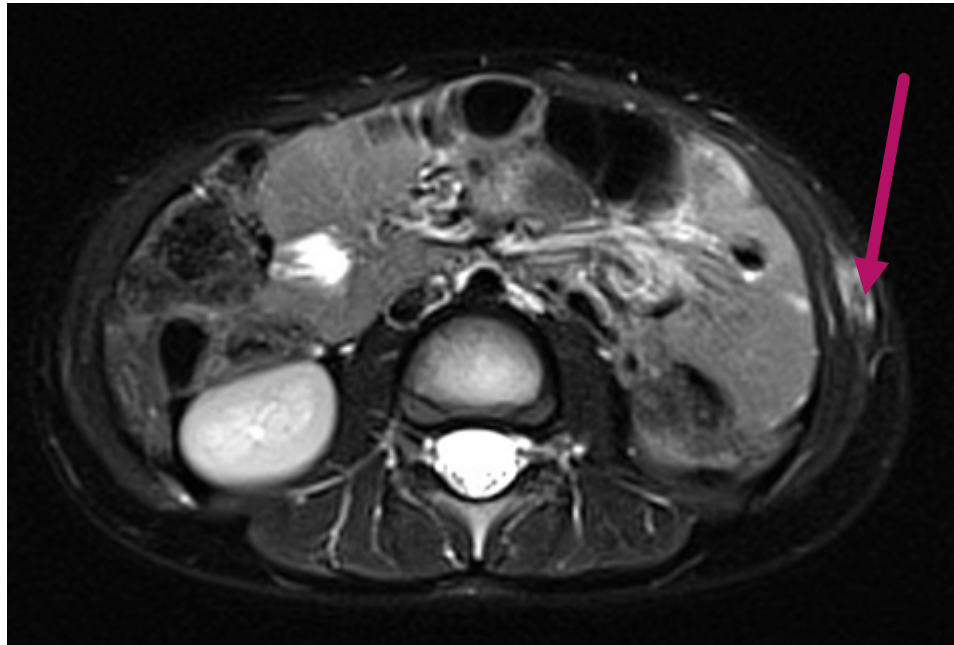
Figure a left chest wall lesion pre-operative post-chemotherapy MRI
